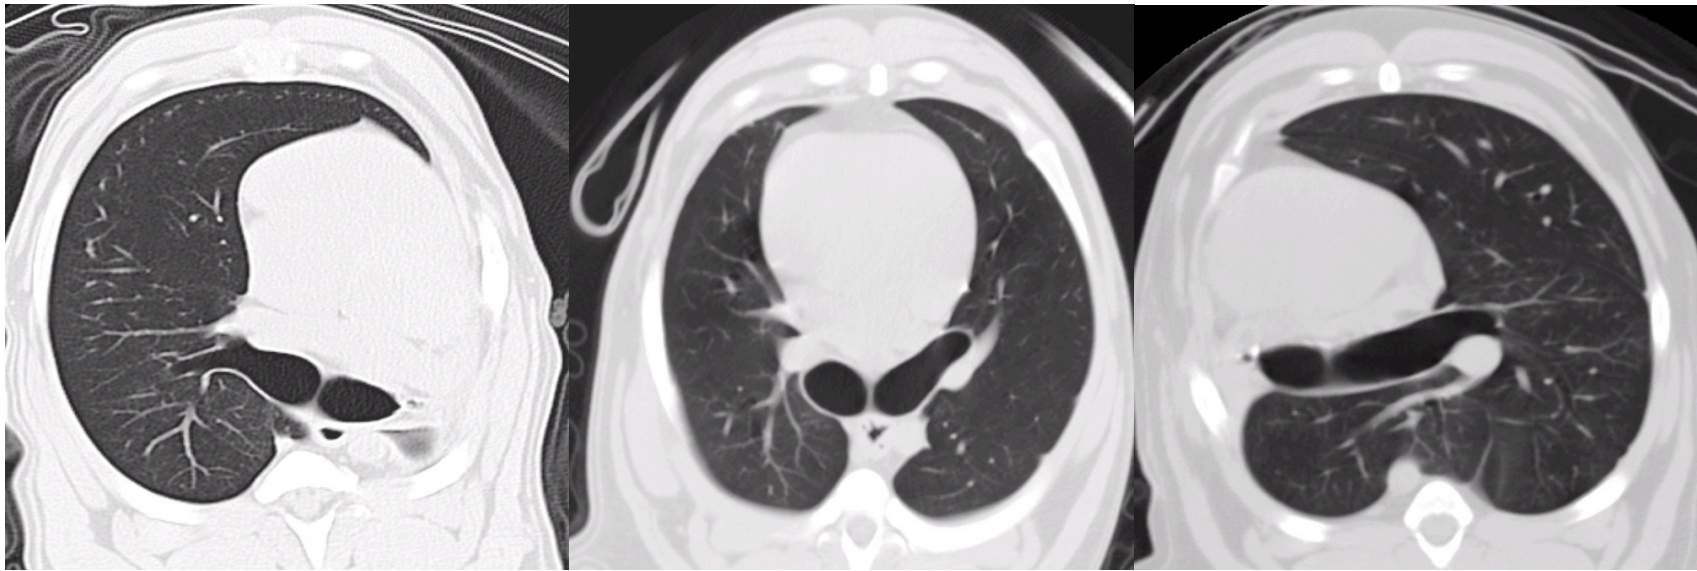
Representative CT images at the level of the carina showing mediastinal shift and enlargement of the remaining lung after left PNX (*left*) or right PNX (*right*) compared with Sham controls (*middle*).
